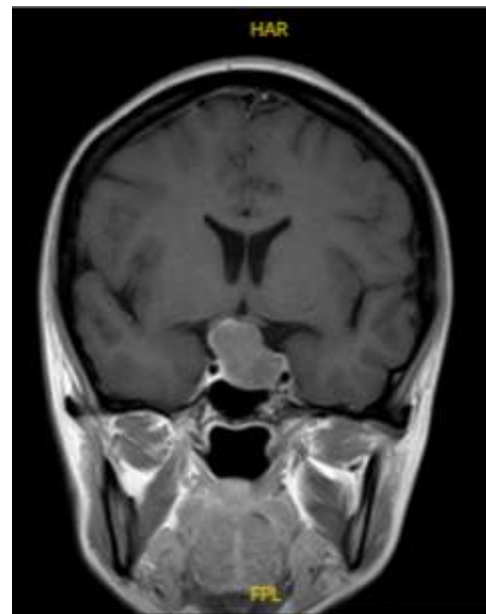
Contrast-enhanced brain MRI: pituitary macroadenoma with optic chiasm compression (Size: $2.13 \times 2.28 \times 3.05$ cm).
